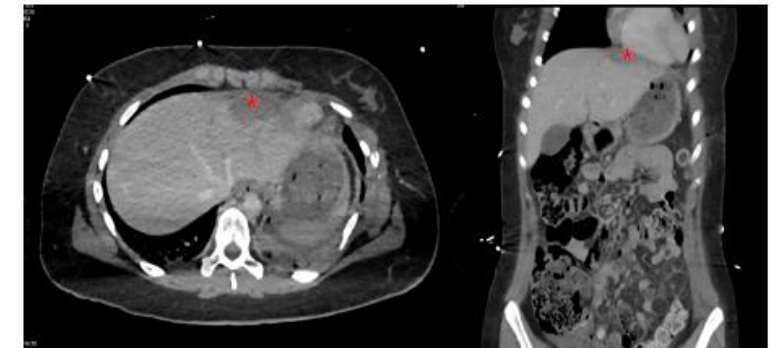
Computed Tomography Axial and Coronal views demonstrating Grade 3 hepatic laceration in Segment 2 *
